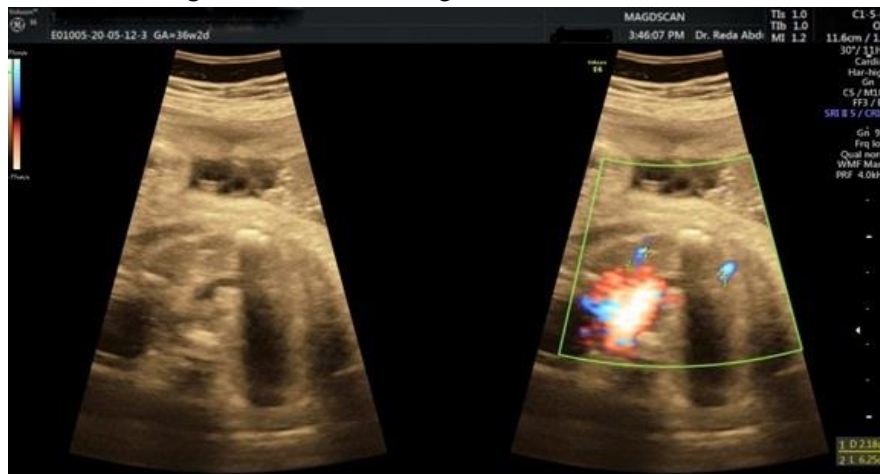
Appearance and measurement of fetal thymus of a patient at the 36 wk+2d of gestation. Using power Doppler ultrasonography with a low pulse repetition frequency of these vessels as described by Paladini et al. 1:trans. diameter 2:perimeter diameter.
